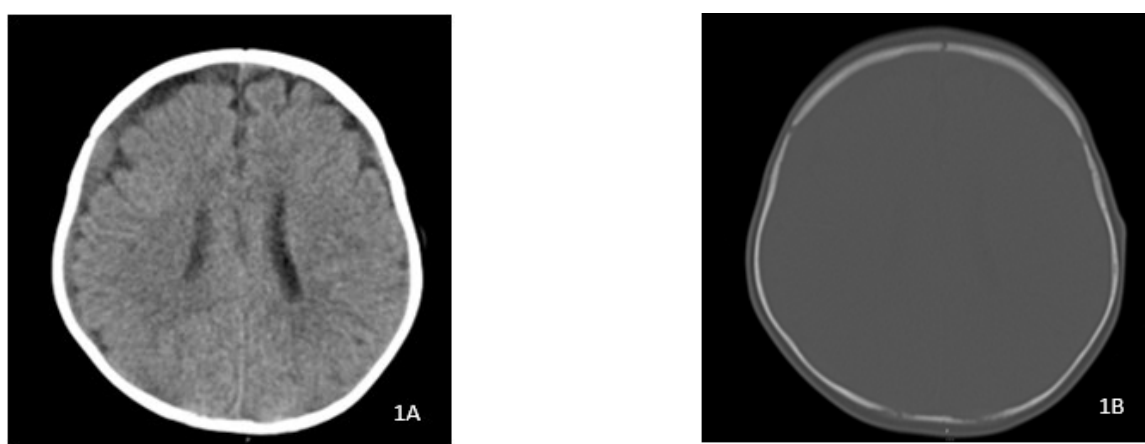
Non-contrast computed tomography of the brain in a 4-month-old boy. (A) A subdural hematoma is present along the right frontoparietal convexity. (B) No demonstrable skull fracture is present.
